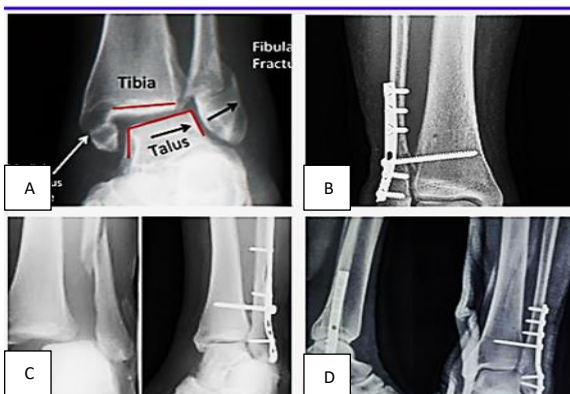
(A-D): Mechanism of injury to syndesmosis. Case 1 post operative x-ray (with syndesmotoc screw fixation through plate), case 2 post operative x-ray (with syndesmotoc screw fixation through plate), case 3 pre and post operative x-ray (with syndesmotoc screw fixation through plate).
